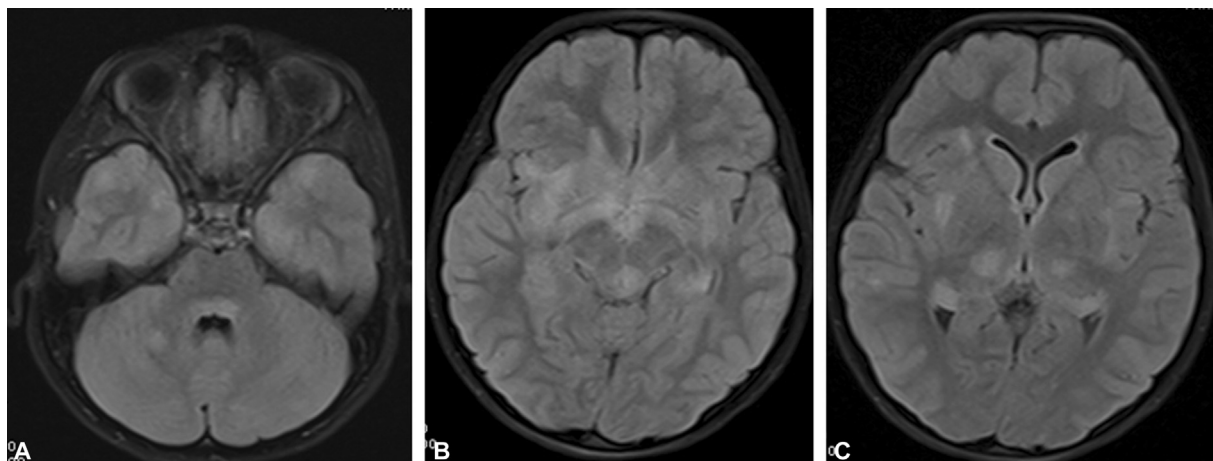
9-year-old with ADEM. (A) Axial FLAIR images show focal and confluent regions of increased signal without mass effect in the right cerebellar hemisphere; (B) midbrain, sublenticular regions, and right subinsular white matter; and (C) bilateral thalami, right external capsule, and right subinsular white matter. FLAIR, Fluid-attenuated inversion recovery.
